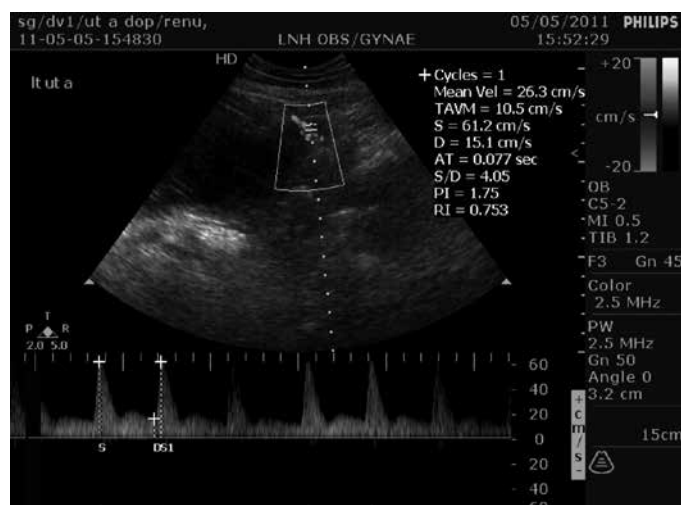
Second trimester uterine artery Doppler showing notching in left uterine artery and pulsatility index >1.45
